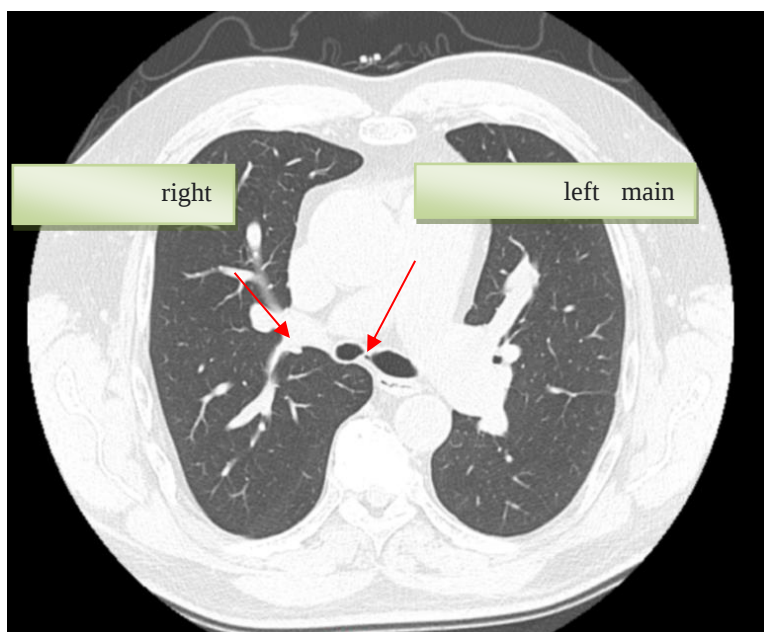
CT scan: - an axial chest CT image with lung window.
